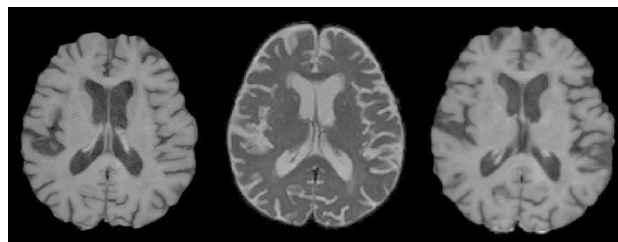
The rigid registration with 6 DOF of the anatomical image of T_1 and the diffusion DWI image acquired at $b = 0$ implemented in the software tools ITK-SNAP and ANTs (a reference image: T_1 and a moving image: DWI image), brain images displayed in the axial plane. On the left: the skull stripped T_1 image, in the middle: the skull stripped diffusion DWI image, on the right: the final fused image.
